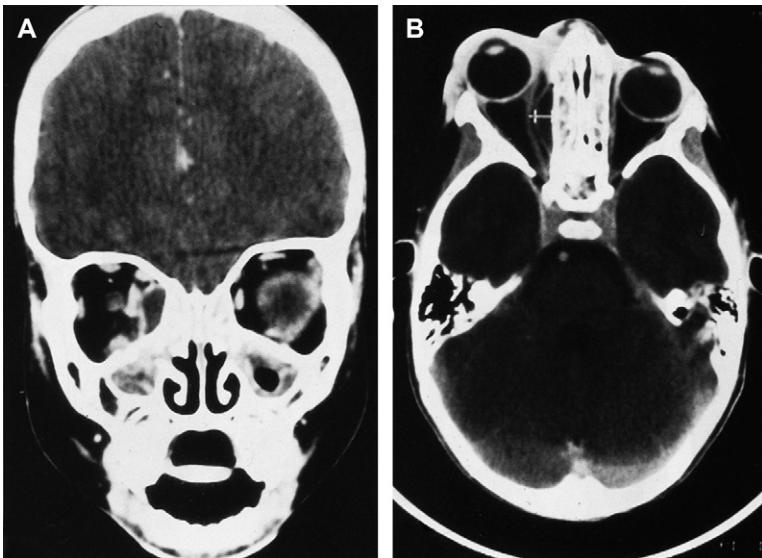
(A) Axial and (B). Coronal CT scans show a subperiosteal abscess extending from the left ethmoid sinus.
